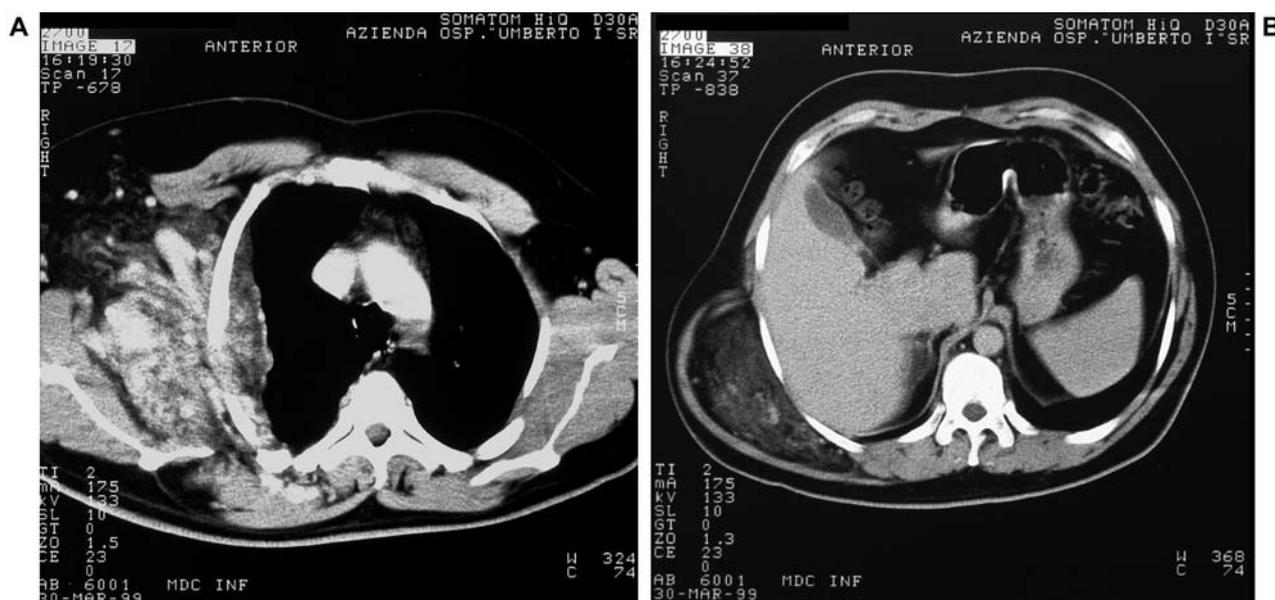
A. Case 1. CT scan. The large mass involves the posterior right hemithorax of the thoracic wall with extension in the right pleural cavity. B. Case 1. The distal extension of the mass.
